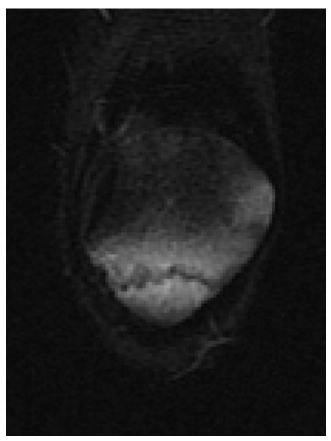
T2-weighted coronal magnetic resonance imaging showing a fracture of the inferior pole of patella.
